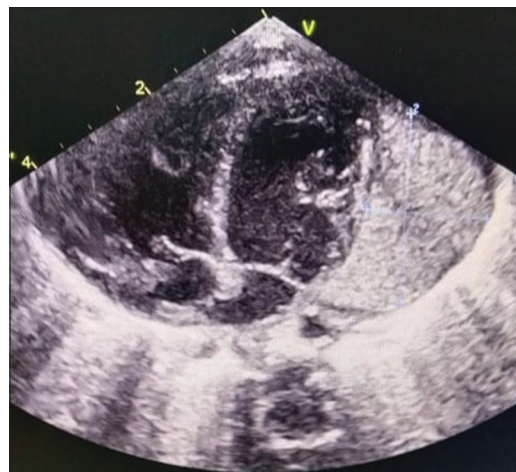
Transthoracic echocardiography on day 2 of life showing echogenic pericardial mass surrounding the left ventricle with no intracardiac extension and mild pericardial effusion
